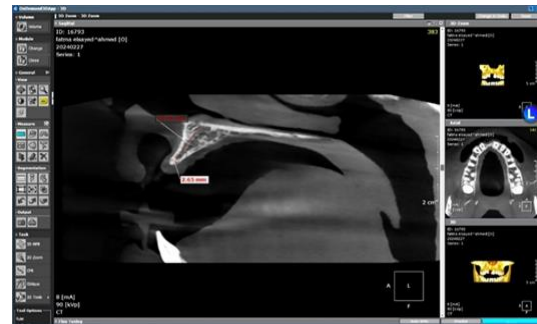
Preoperative CBCT measurement for both width and height for
